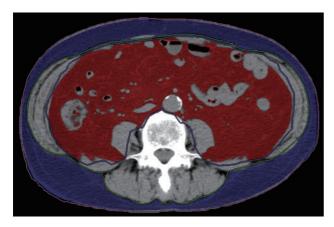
Findings from computed tomography imaging Red and blue areas indicate VFA and SFA, respectively.
